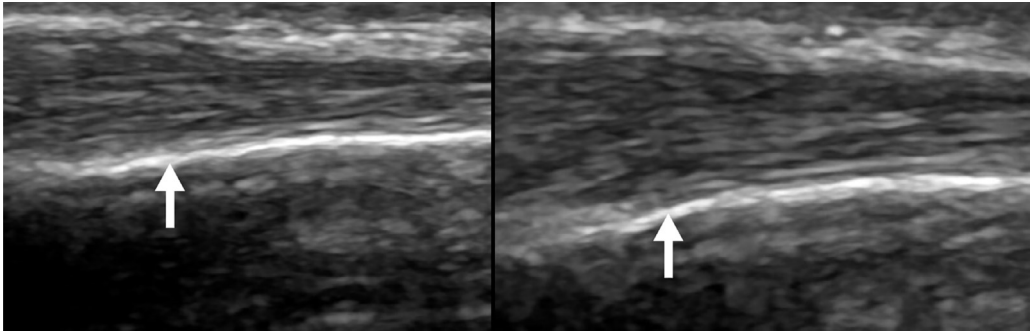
Pre- and Posttreatment Ultrasound Images of De Quervain's Tenosynovitis. Displayed are the sequential ultrasound images demonstrating the first extensor compartment of the wrist affected by De Quervain's tenosynovitis. The left image reveals the pretreatment condition, characterized by thickened retinaculum and swollen sheath indicative of inflammation. The right image shows the compartment posthydrodissection treatment, highlighting the reduced inflammation and decompressed tendons, signifying a successful therapeutic response.
